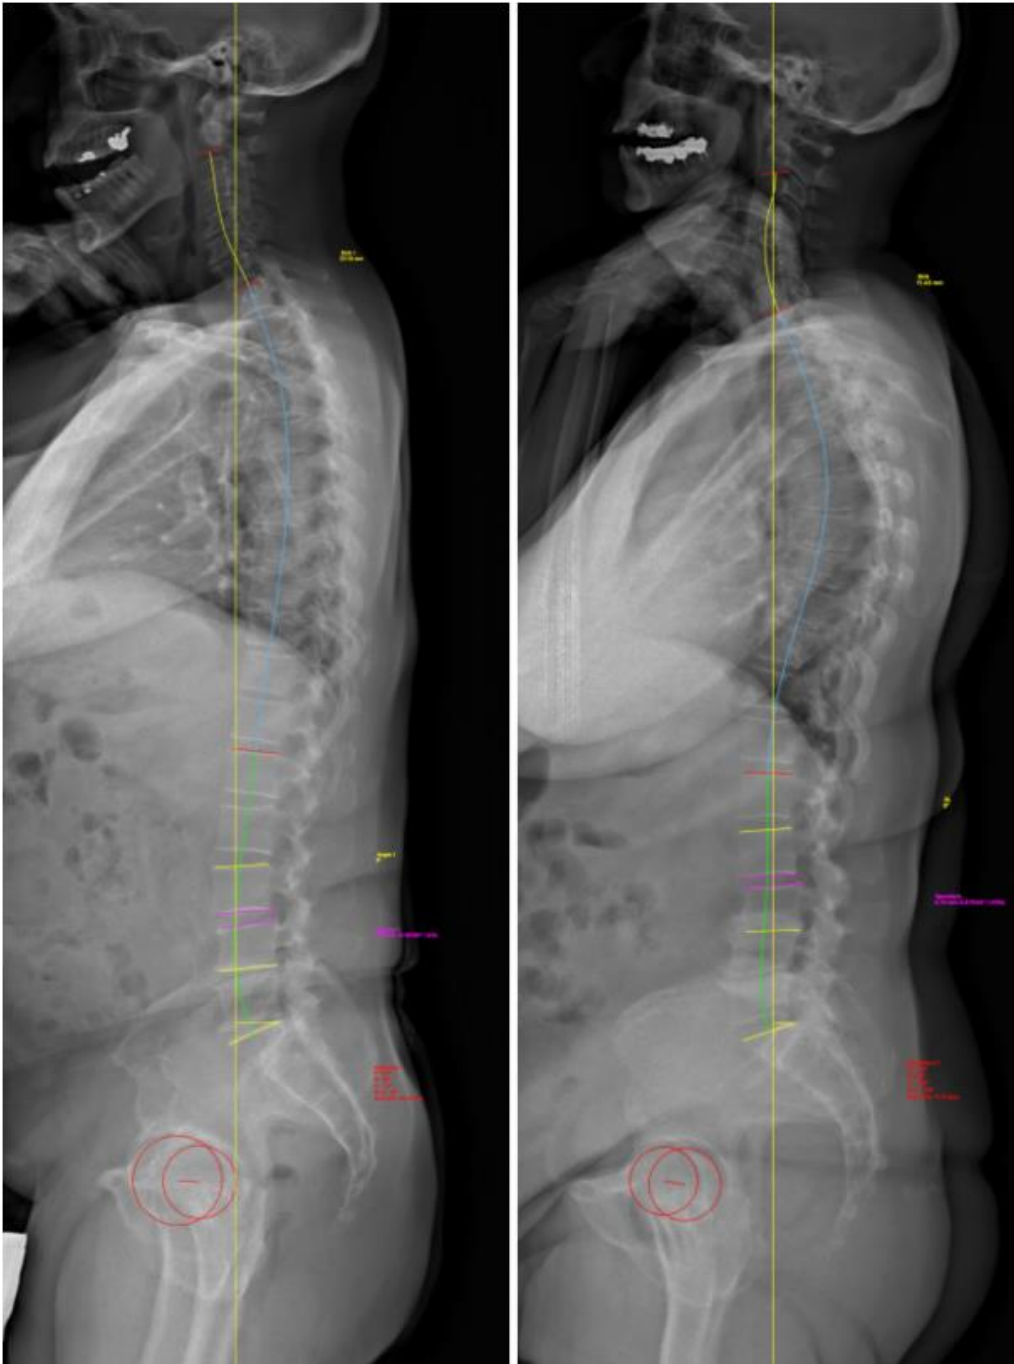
Type 2 on lateral standing low-dose X-ray view. Altered global LL, compensated malalignment
